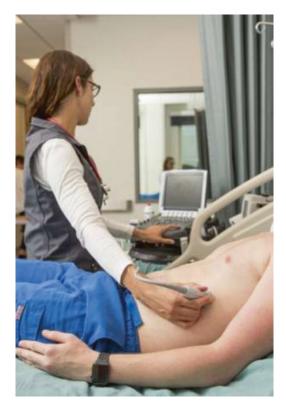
Ultrasound ergonomics. Proper positioning is key to good image acquisition
